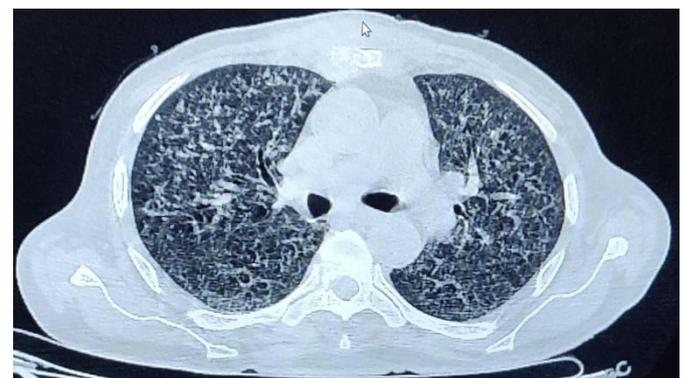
CT chest (sagittal section) showing features of miliary tuberculosis.
